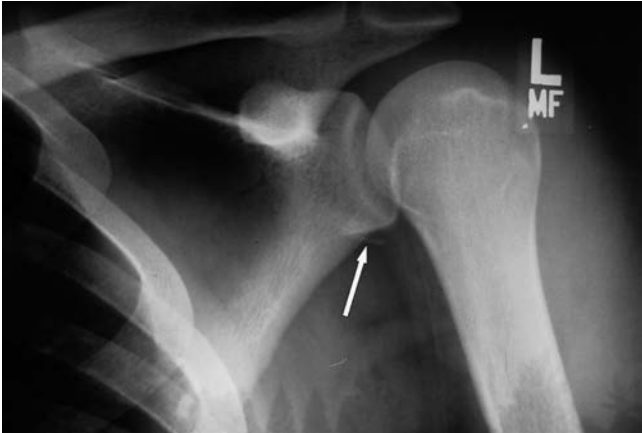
Although radiographically subtle, the Bankart fracture is a small avulsion of the inferior rim of the glenoid. The loss of the glenoid labrum destabilizes the glenohumeral joint and nearly ensures recurrent dislocations.
